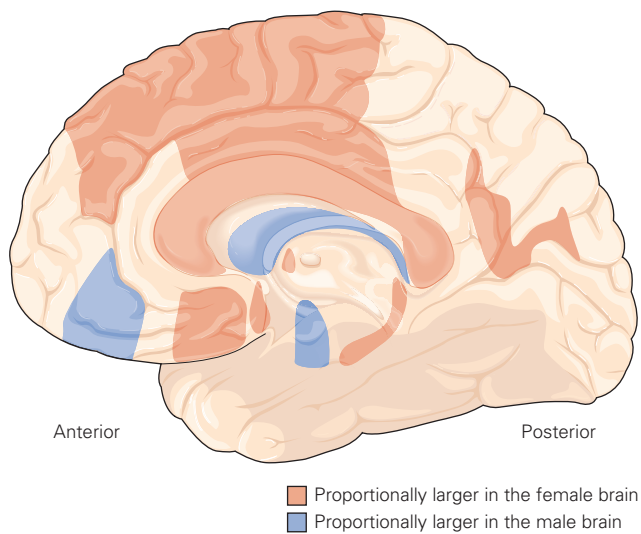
Sexual dimorphism is widespread in the adult human brain. A magnetic resonance imaging study measured the volume of many brain regions in adult men and women. The volume of each region was normalized to the size of the cerebrum for both sexes. Sex differences were significant in many regions, including several cortical areas that likely mediate cognitive functions. (Adapted, with permission, from Cahill 2006. Copyright © 2006 Springer Nature.)
